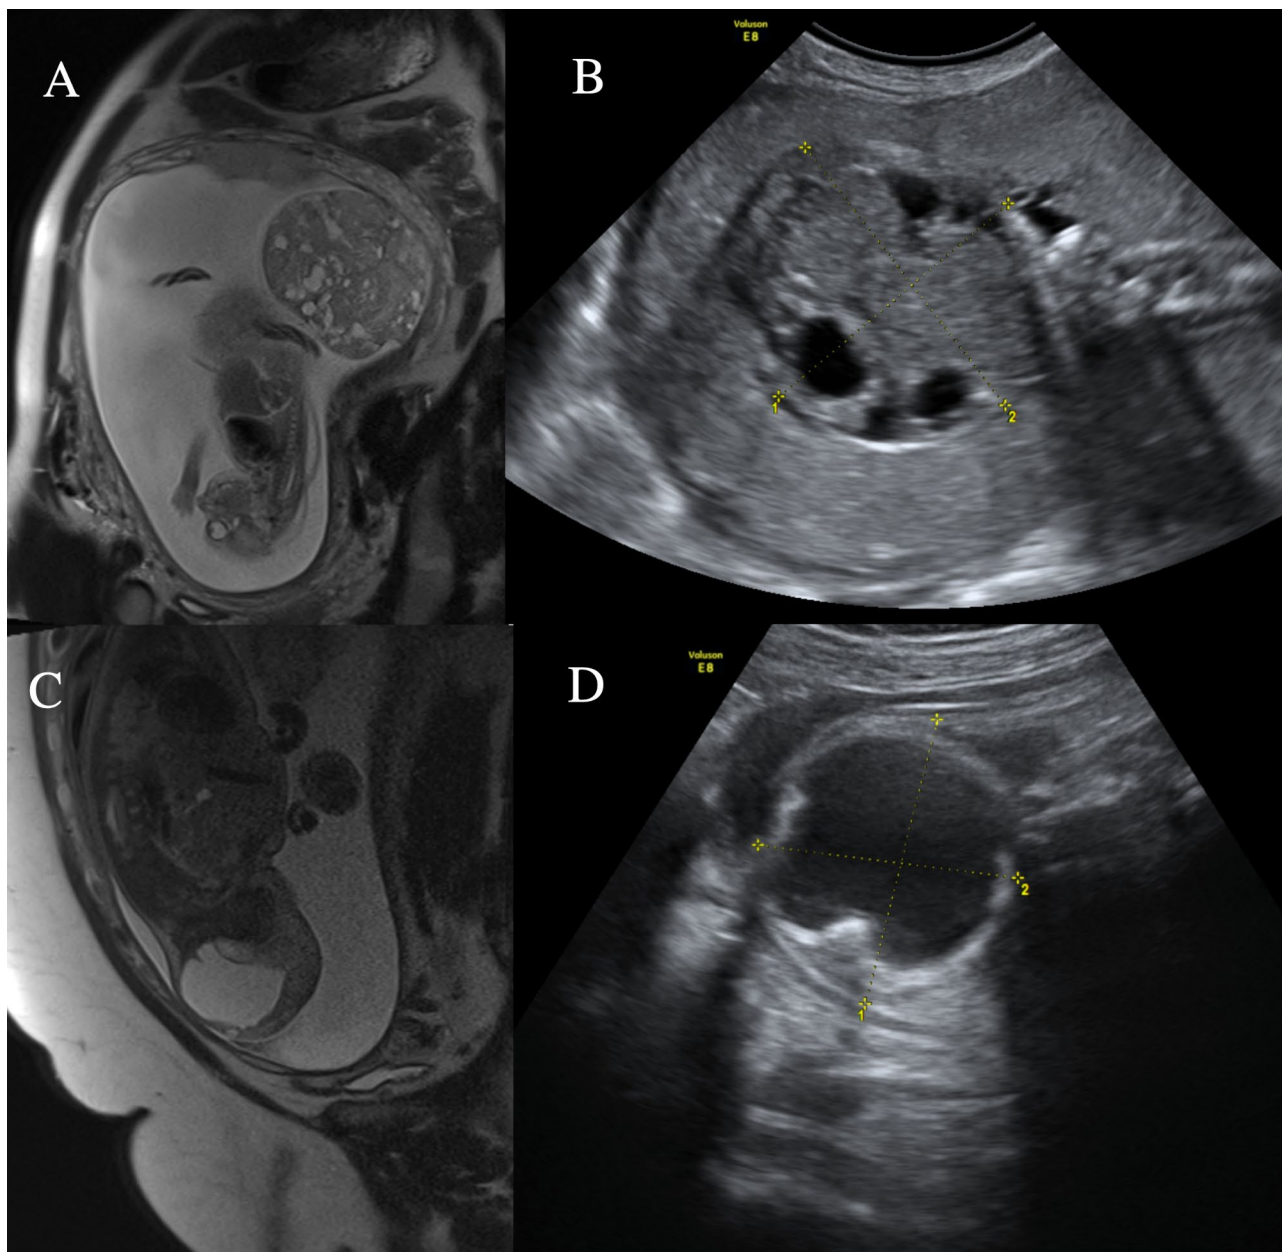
A. Fetal magnetic resonance imaging in the fetus, 23rd weeks of gestation (case 1, terminated pregnancy). B. Ultrasound finding in the fetus, 22nd weeks of gestation (case 1, terminated pregnancy). We described a solid teratoma 10 cm in size. C. Fetal magnetic resonance of the SCT, 28th weeks of gestation (case 3). D. Ultrasound imaging of the SCT, 21st weeks of gestation (case 3)
